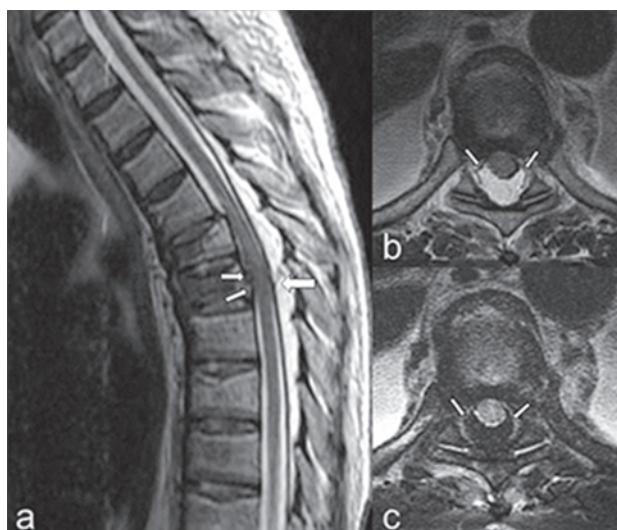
a) Sagittal T2-weighted MR image showing distraction of the PLC at T4-5 level (arrow) associated with mild retropulsion of the T5 and T6 posterior vertebral body wall (small arrows). b) Axial T2-weighted and c) corresponding axial T2-weighted fat-saturated MR images show the posterior, rounded, oblong encapsulated soft tissue mass with lipomatous signal intensity (small arrows).
